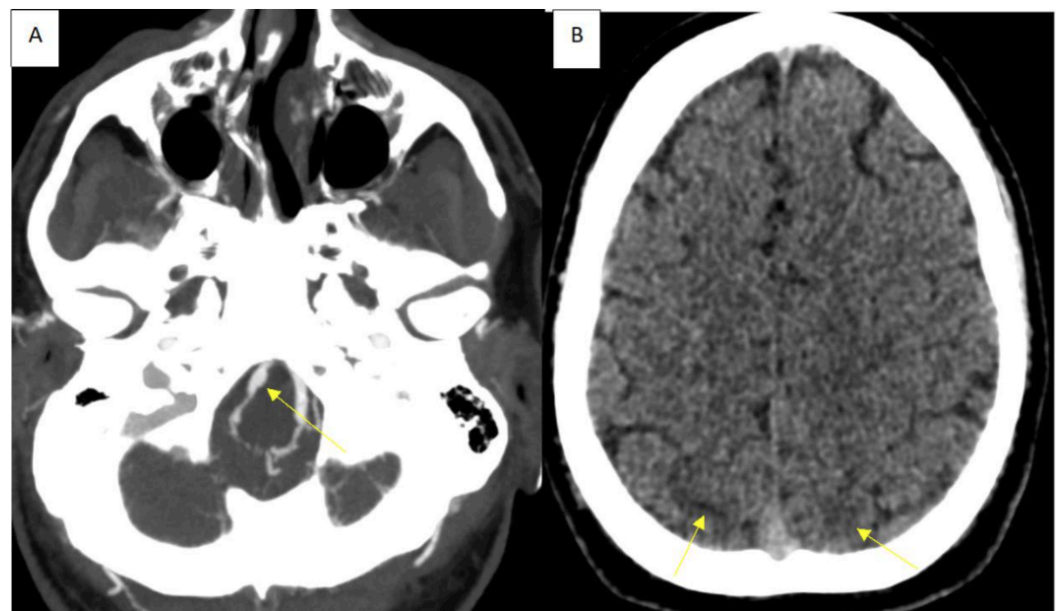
Computed tomography angiogram (CTA) and unenhanced computed tomography (CT) head imaging on day 10 during his deterioration. (A) CTA showing persistent irregularity of the right vertebral artery with new pseudoaneurysm formation (yellow arrow). (B) CT head showing symmetrical oedema in the posterior parietal lobes (yellow arrows).
